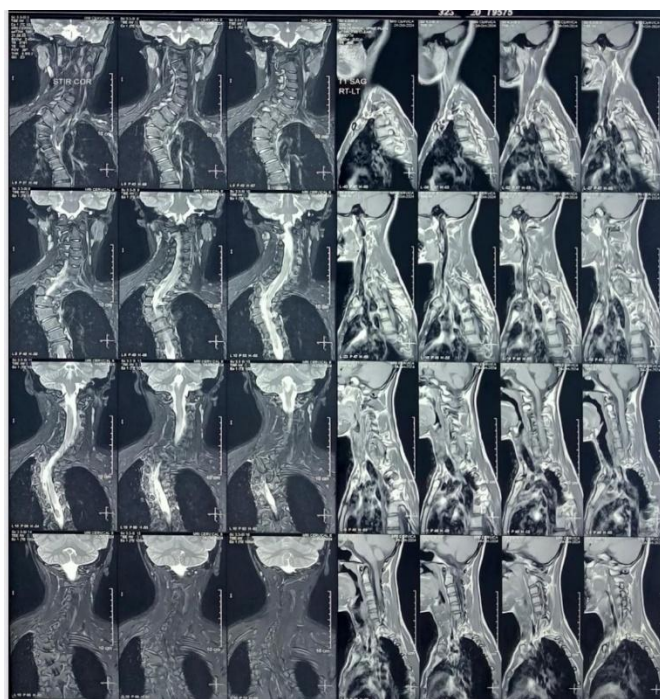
Showing MRI scans of patient
